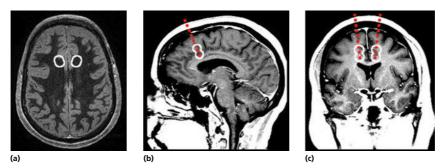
Anterior cingulotomy. (a) Axial Fast Grey Matter Acquisition T1 Inversion Recovery (FGATIR), (b) sagital T1-weighted, gadolinium-enhanced and (c) coronal T1 gadolinium-enhanced brain magnetic resonance images demonstrating the typical target, entry point and trajectory for an anterior cingulotomy. The dashed line indicates approximate electrode trajectory and the white circles indicate the approximate extent of lesion generation. The approximate target for an anterior cingulotomy is defined as a point in the ACC that is 2–2.5 cm posterior to the tip of the frontal horn of the lateral ventricle (out of the plane of the figure), 7 mm from the midline and 1 mm above the roof of the ventricles bilaterally. The total final cingulotomy lesion is approximately 2 cm in height and 8–10 mm in diameter.
